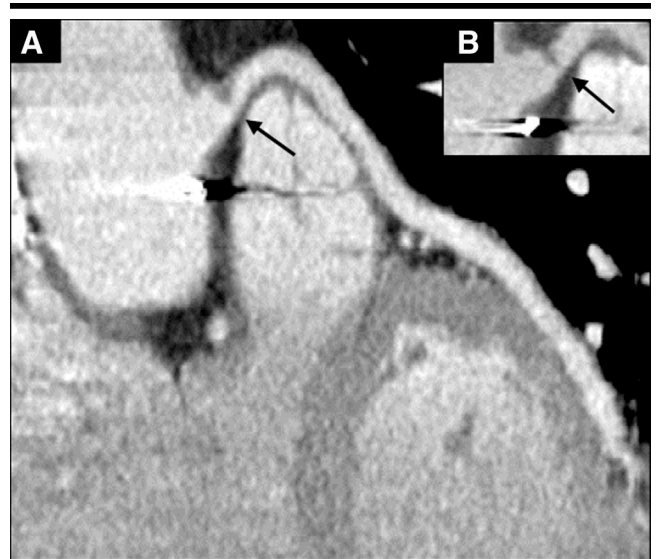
Progressing stenosis of coronary artery bypass graft at four-detector row CT. *A*, Craniocaudal curved multiplanar reconstruction and, *B*, corresponding 12-month follow-up image demonstrate focal asymmetric narrowing (arrows) of the proximal portion of aortocoronary venous graft to the middle left circumflex coronary artery. Initial ~70% narrowing progressed to ~90% narrowing and was accompanied by worsening angina.
